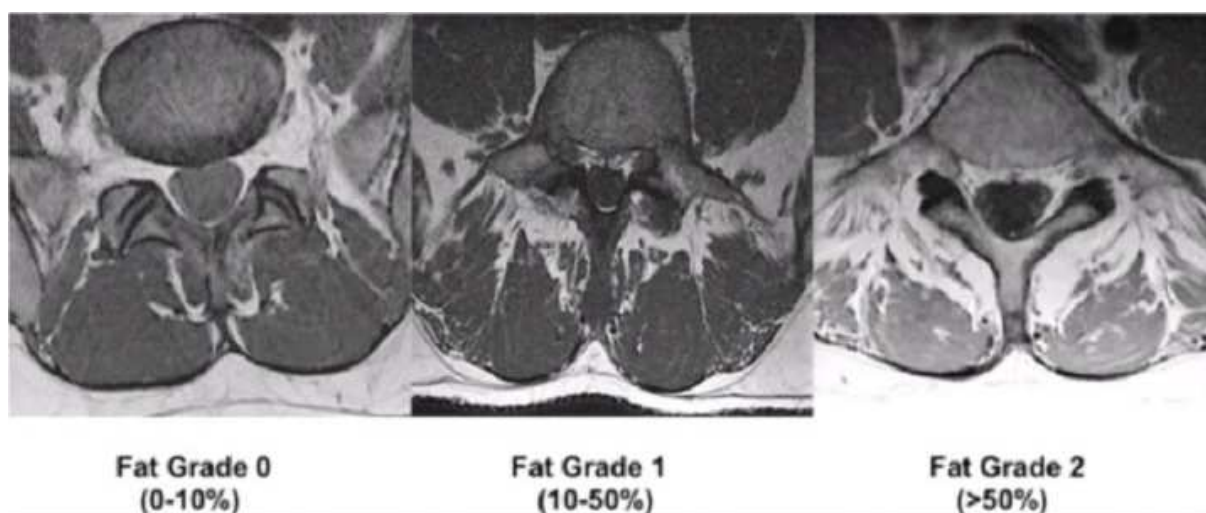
Grading of MR images with different muscle-fat components of the lumbar multifidus muscle.
